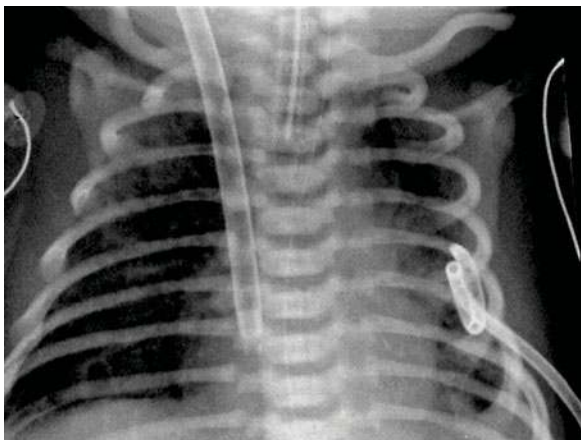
Frontal chest radiograph showing areas of air trapping alternating with areas of atelectasis – classic features of neonatal MAS
